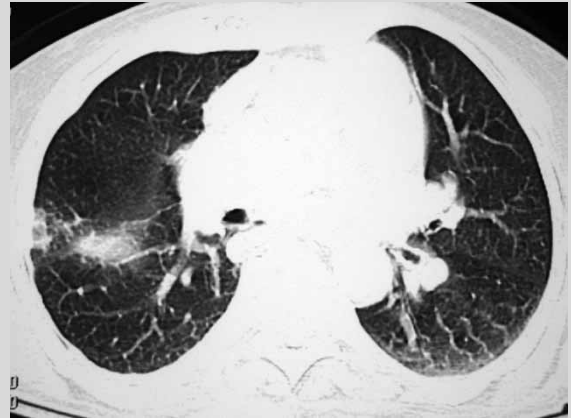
Thorax CT of the parenchyma
